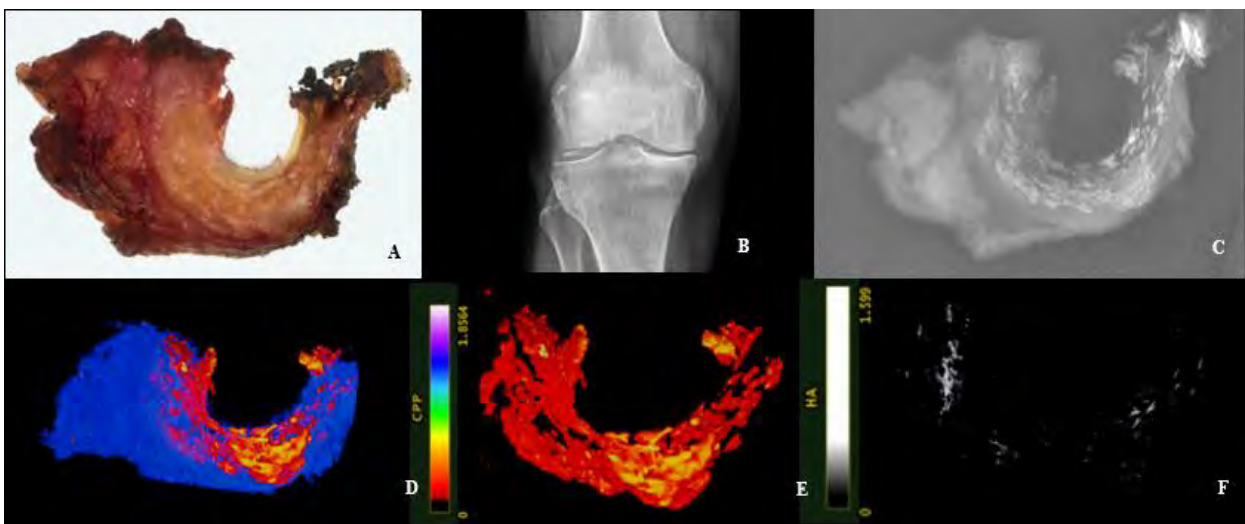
(A) Photo of the excised meniscus, (B) Plain X-ray of the knee before surgery, (C) Plain X-ray of the meniscus, (D) SPCCT image, (E) SPCCT image showing only CPP deposits, (F) SPCCT image showing only HA deposits.
